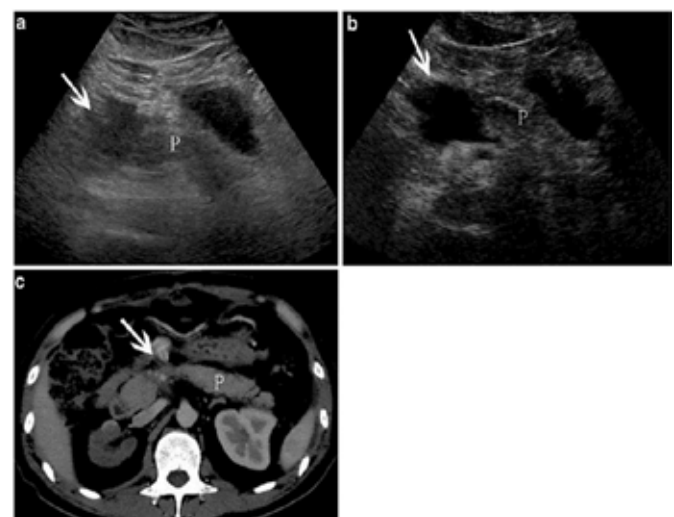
Pancreatic trauma in adults. Images "a" and "b" are from ultrasound, image "c" is from the computed tomography<sup>4</sup>.
